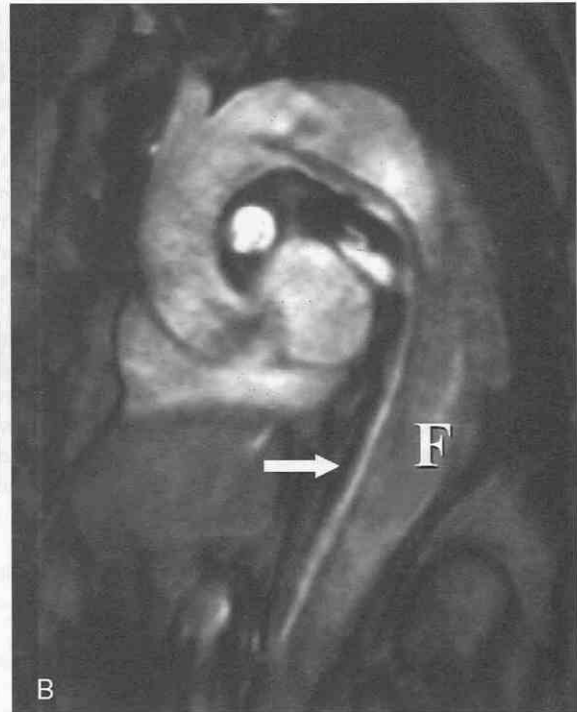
A, Axial cine gradient-recalled echo (GRE) MR image shows type B dissection, with a smaller, compressed true lumen and a posterior false lumen (F). B, Sagittal oblique cine GRE image in a patient with dissection shows bright signal in anterior true lumen, consistent with faster flow (arrow). F = false lumen. Arrow denotes thrombus surrounding the false lumen.
